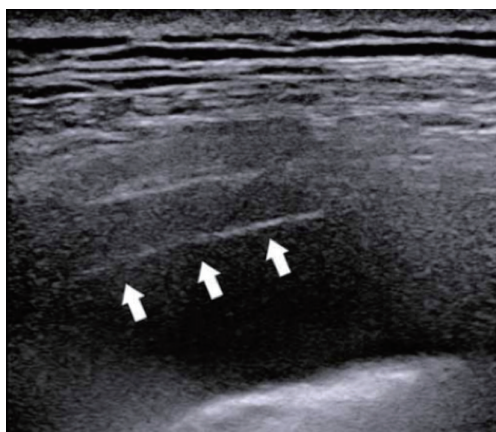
Transthoracic ultrasound demonstrating parietal pleural thickening (white arrows).
